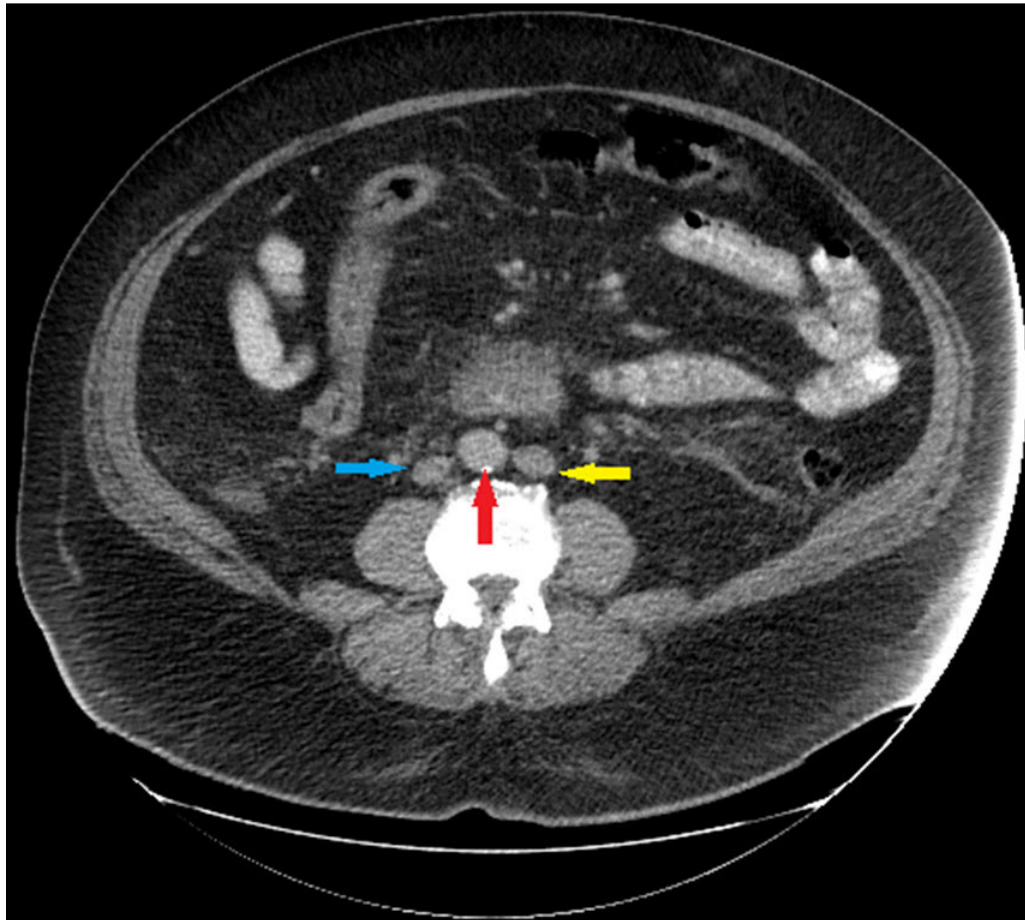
Transverse abdominal CT showing normal right-sided IVC (blue arrow), abdominal aorta (red arrow), and left-sided IVC (yellow arrow)
